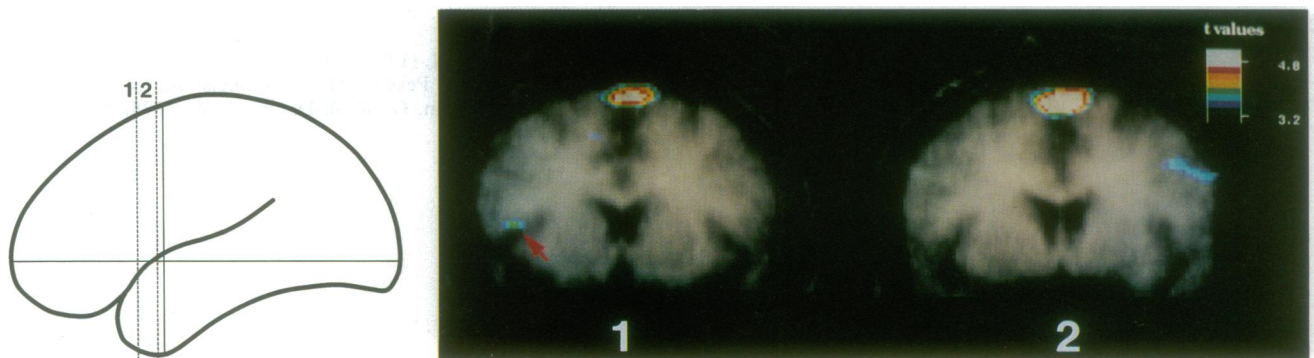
Self-ordered minus externally ordered task. Merged PET-MRI coronal section 1 at 12 mm and section 2 at 3 mm to show activation of Broca's area (indicated by the arrow in section 1) and the supplementary motor area.
